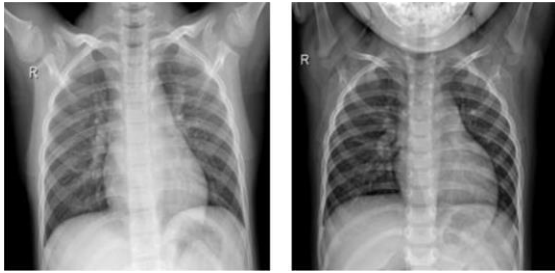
Representative chest X-ray images of normal[23].
